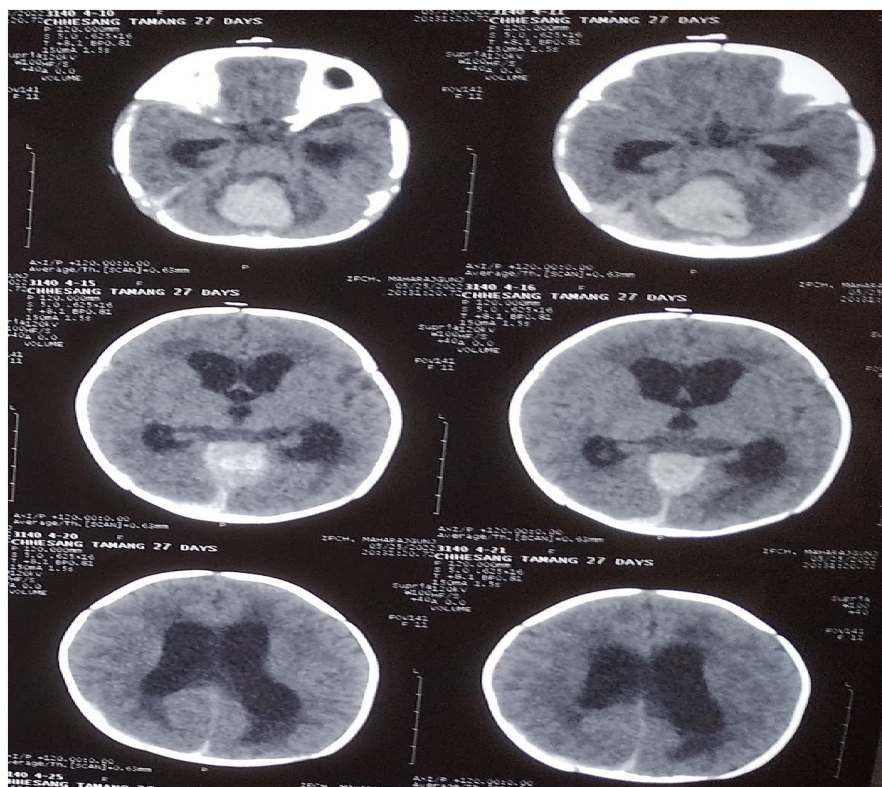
Plain computed tomography scan showing a hyperdense mass in the posterior fossa arising from the cerebellum, causing obstructive hydrocephalus.
